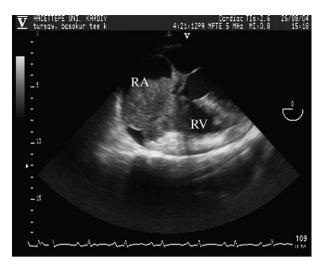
A transesophageal echocardiographic view showing a large tumour mass occupying most of the right atrium and prolapsing through the tricuspid valve into the right ventricle, causing right ventricular inflow obstruction.
